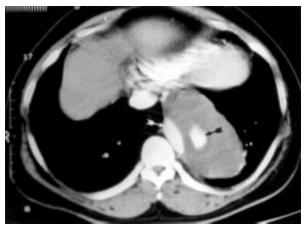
Computed tomographic scan demonstrates large descending thoracic aneurysm. Contrast is seen in true lumen (white arrow) as well as false lumen (black arrow). A massive amount of clot is seen within false lumen.
